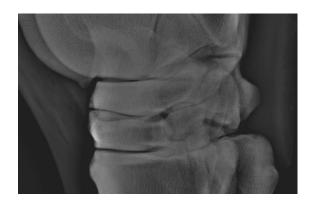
Lateromedial radiographic image of the left tarsus of case 1. There is diffuse increased opacity of the dorsal aspect of the central tarsal bone, which is slightly wedge-shaped.
